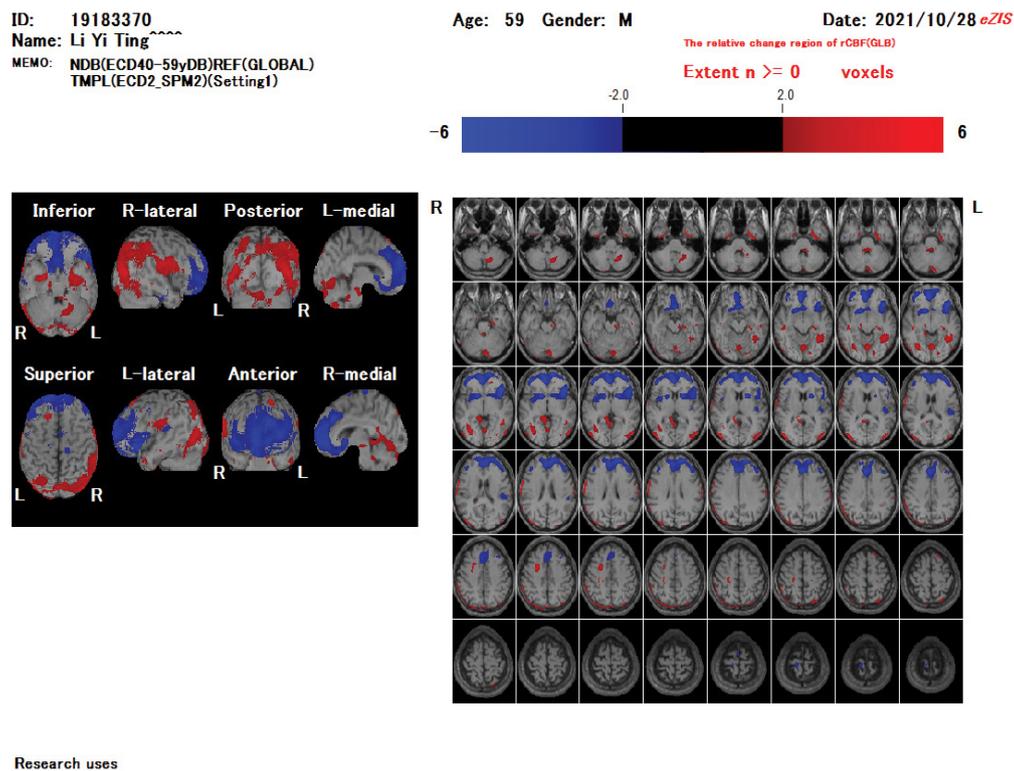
Difference of change of perfusion of whole brain in axial view of perfusion brain SPECT. Red means increased uptake and blue decreased uptake. SPECT: Single-Photon Emission Computed Tomography
